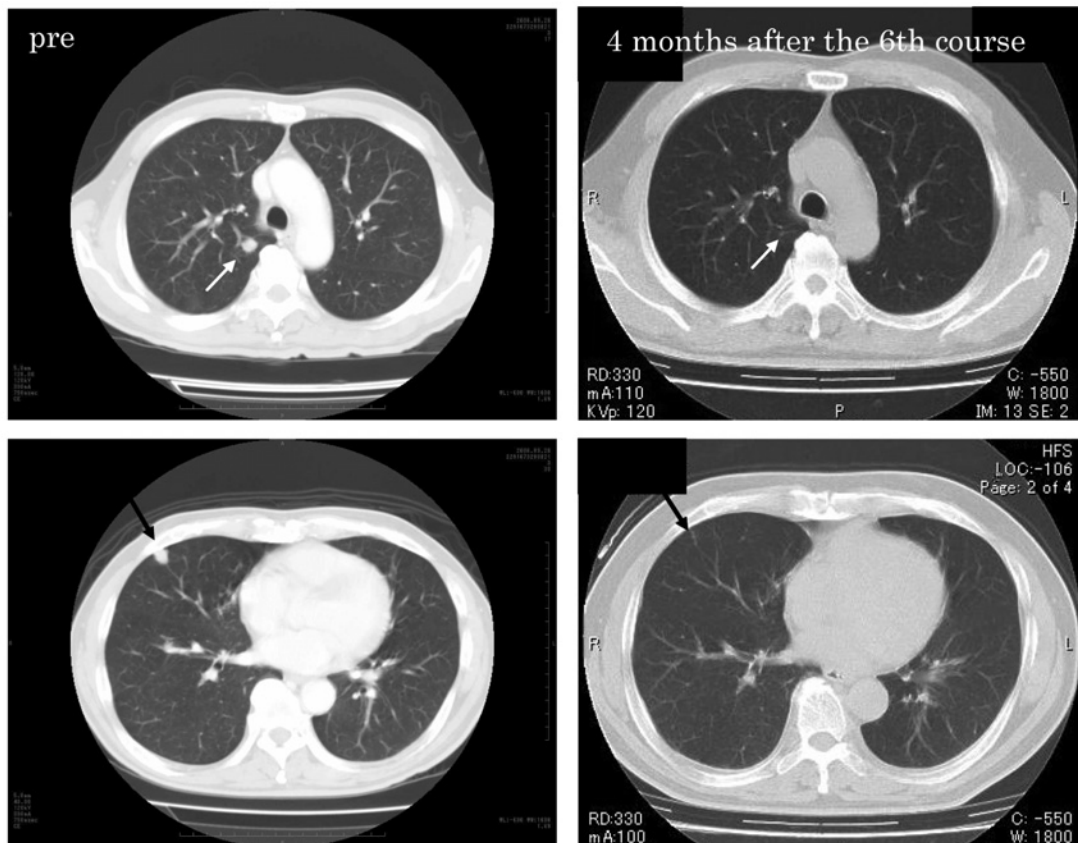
Chest CT examinations of the patient were taken at 4 time points, namely, before entry into the clinical trial, after 3 courses of the therapy, and at 1 and 4 months after the 6th course of the therapy. In this figure we show representative CT images obtained before entry into the clinical trial and 4 months after the 6th course of the therapy.
